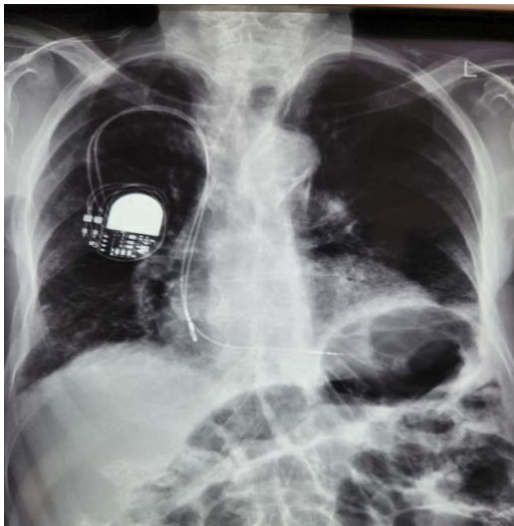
Normal chest radiograph with no visible migrated cannula
